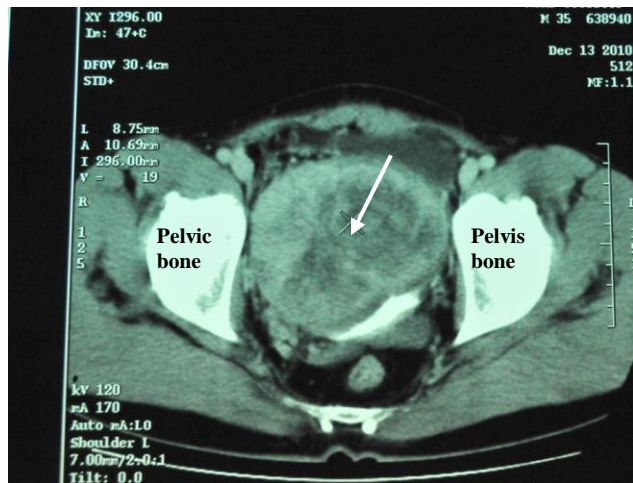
CECT picture showed a heterogeneous mass seen in pelvis measuring 94x81 mm in size compressing urinary bladder (arrow). Exact origin of mass not clear on CT but tumor showing a close proximity with left sided pelvic bone and bladder wall.
